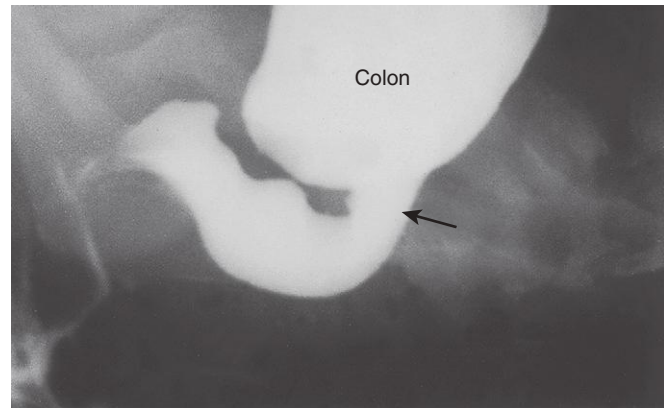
Radiograph of the colon after a barium enema in a 1-month-old infant with congenital megacolon (Hirschsprung disease). The aganglionic distal segment (rectum and distal sigmoid colon) is narrow, with distended normal ganglionic bowel, full of fecal material, proximal to it. Note the transition zone (arrow).
